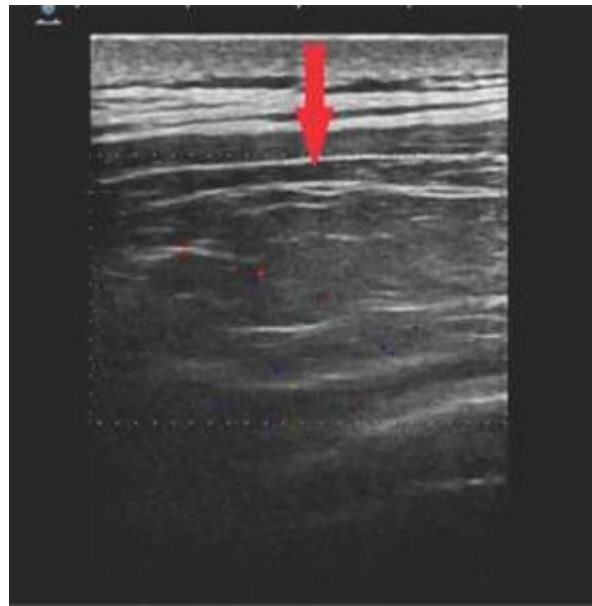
Ultrasound and Colour Doppler showing Oval Well Defined Compressible Encapsulated Mass with Echo-Pattern Similar to Fat with No Calcification within Mass and No Colour Flow on Doppler Suggesting No Vascularity. Linear Internal Echogenic Incomplete stripes Noted in the Mass.
